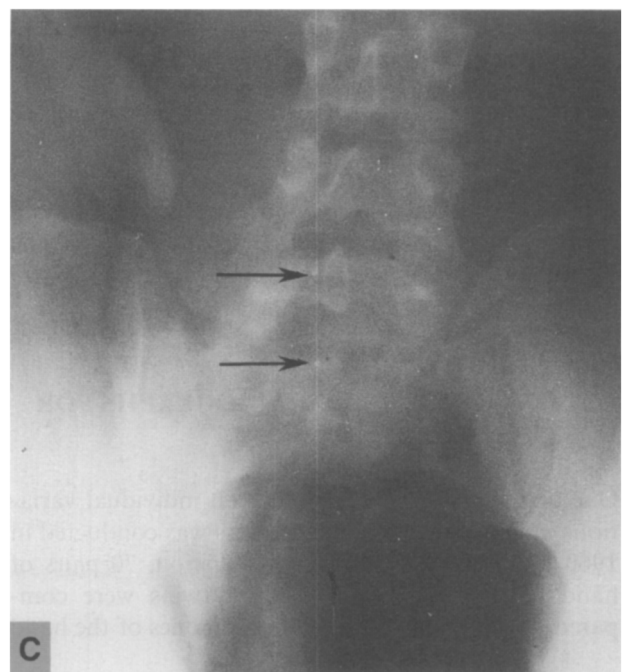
(A) Radiograph during myelography. (B) Antemortem: residual contrast medium following myelography, seen during intravenous phlebography. (C) Postmortem: evidence of residual contrast medium used during myelography.
